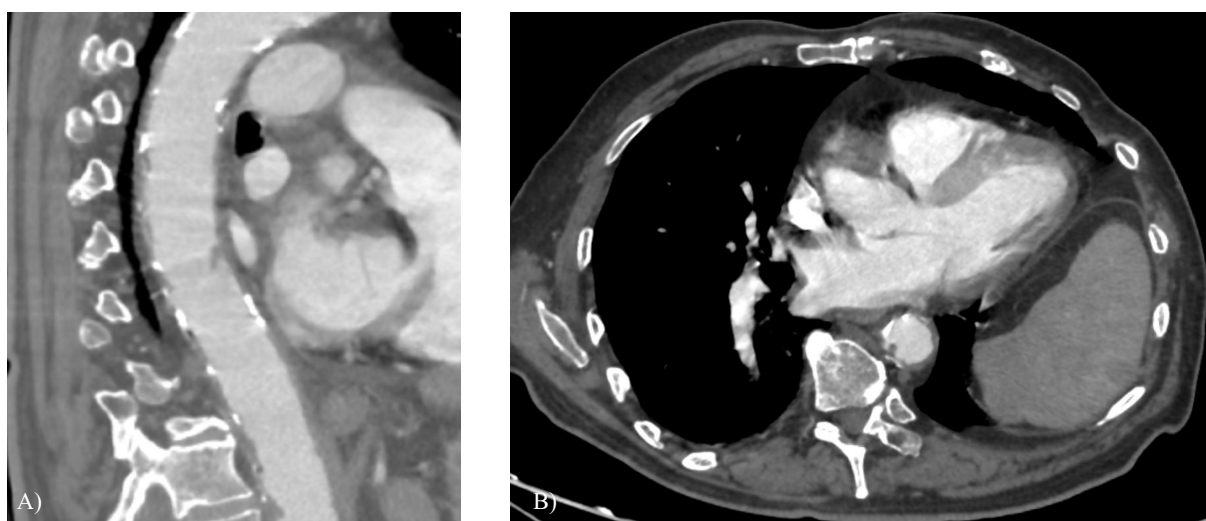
Aortic computed tomography angiography following one month of conservative treatment. A) Curved multiplanar reconstruction demonstrating the thrombus's complete resolution while the underlying atherosclerotic lesions are still visible. B) Axial image at the level of thrombus confirming the findings.
